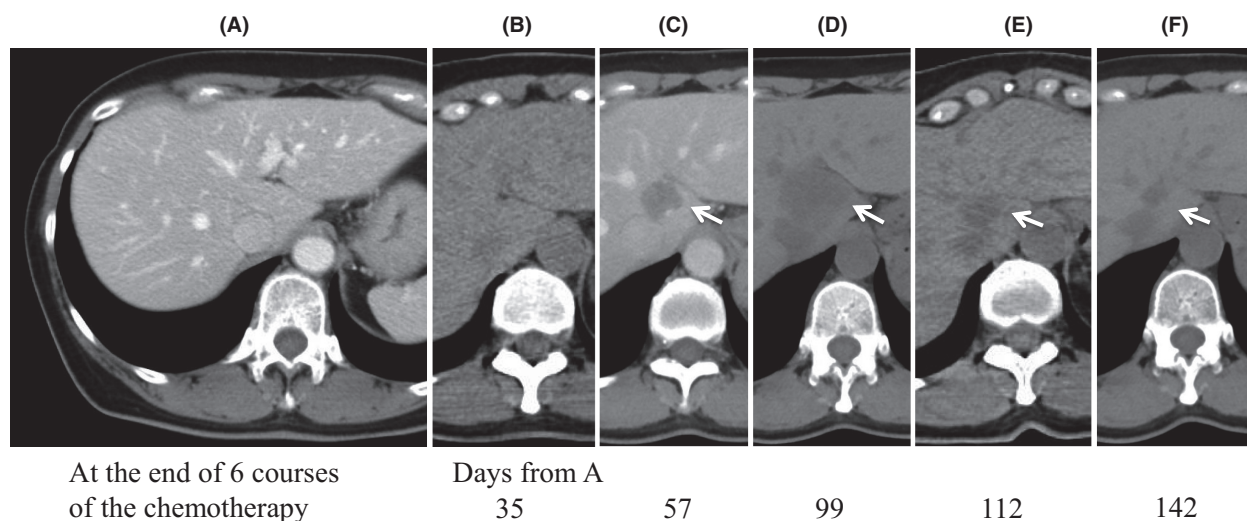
CT images in the metastasized liver lesion. (A) After three courses of chemotherapy. (B) Just before the first vaccination with AFTV. (C) After the third vaccination with AFTV. Arrow indicates the metastasized lesion. (D) Two days before the third treatment with 1 mg/kg pembrolizumab. The liver lesion reached a maximum diameter of 4.2 cm. (E) Eleven days after the third treatment with pembrolizumab. (F) After additional irradiation of the liver-metastasized lesion with a cyber-knife (49 Gy) and the fourth treatment with pembrolizumab. Below the arrow, inferior vena cava is seen. (A, C) Contrast-enhanced images. (B, D–F) Non contrast-enhanced images.
